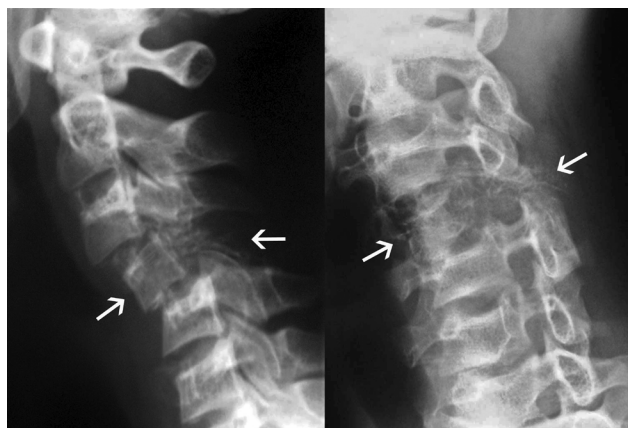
Cervical spine radiographs of a 12-year-old boy with Ewing sarcoma. Note the permeative osteolytic lesion involving the C4 vertebral body and posterior elements (straight arrows), with a radiolucent matrix and subluxation at C3–C4 and C4–C5.
